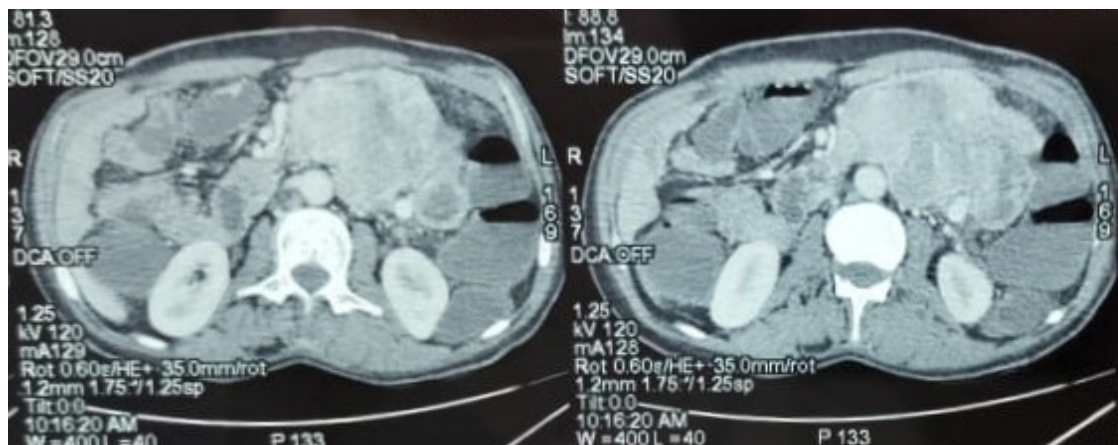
Contrast-enhanced abdominal CT scan revealing two tumoral masses arising from the fourth portion of the duodenum (D4) and the angle of Treitz, suggestive of gastrointestinal stromal tumors
